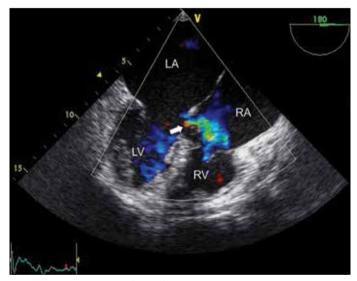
Supravalvular (direct) Gerbode defect in transesophageal echocardiography four-chamber (180°) view
